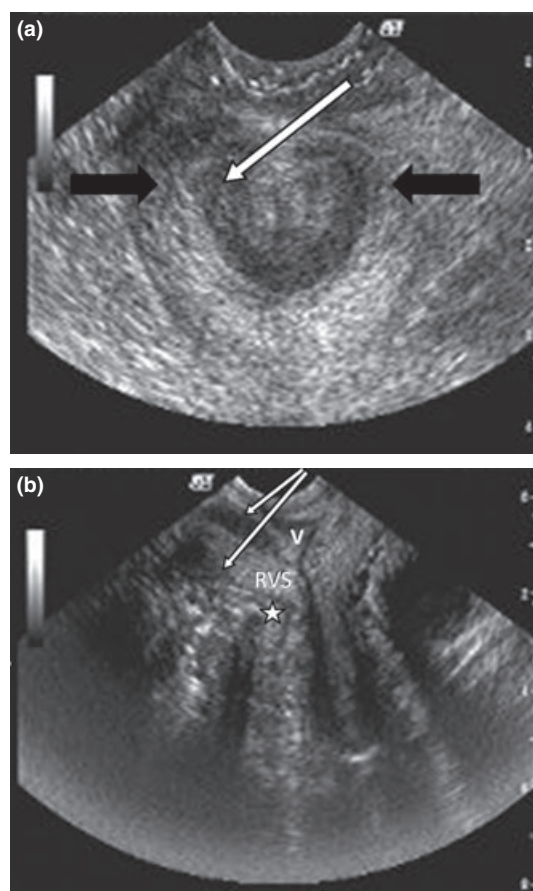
(a) Axial transperineal ultrasonography (TP-US) image showing landmarks that are similar to those obtained with two-dimensional endoanal ultrasound. The internal anal sphincter appears as an hypoechoic ring (white arrow) with the external anal sphincter appearing as an hyperchoic complete ring flattened anteriorly (black arrows). (b) Sagittal TP-US image. The hypoechoic internal anal sphincter (arrows) is identified above and below the anal canal in profile. The area of the puborectalis is seen end-on (star). The vagina (V) may be instilled with contrast if required to delineate the recto-vaginal septum (RVS).
